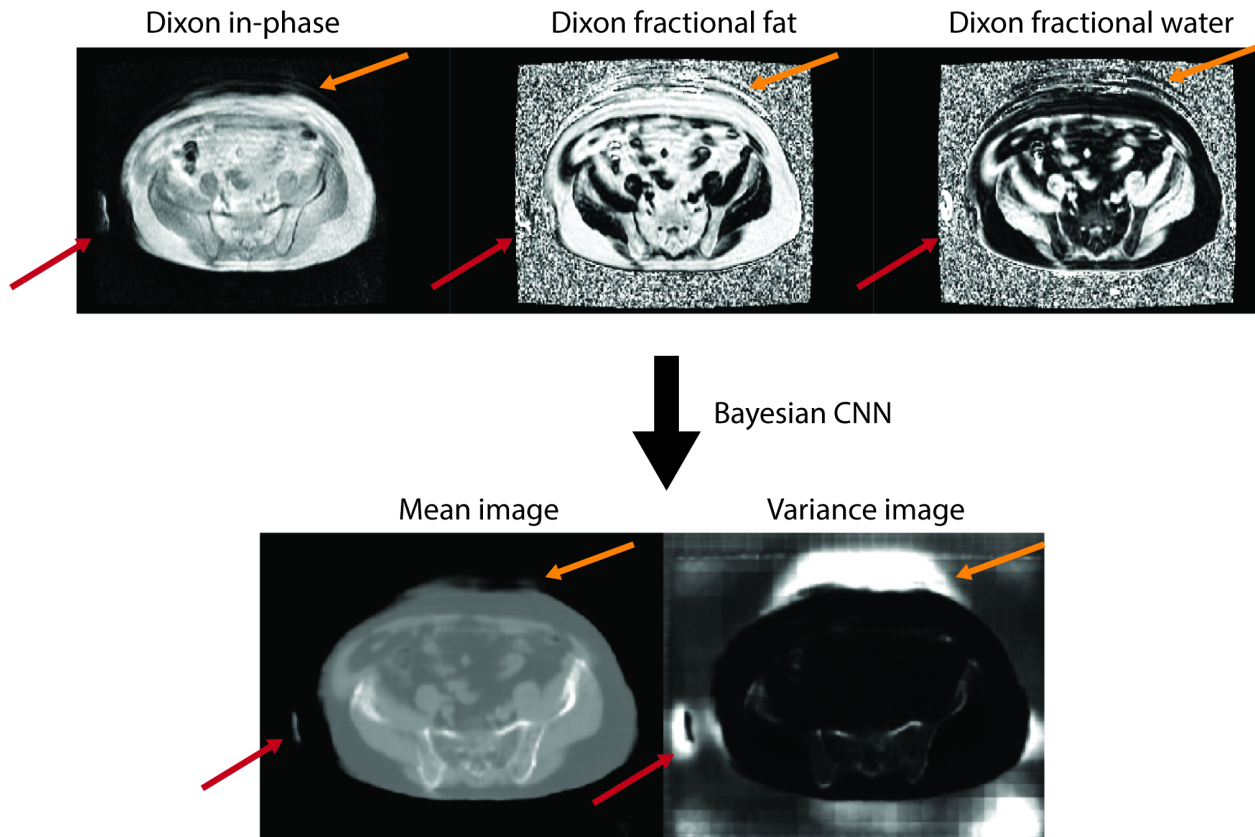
Result of uncertainty estimation on without body masks on an MRI with motion artifacts due to breathing and arm truncation due to edge of field-of-view inhomogeneity. The orange arrow points to a region where motion artifacts were present and the dark red arrow points to a region with arm truncation. Both artifact regions were highlighted in the variance image without the network being explicitly trained to highlight these regions.
